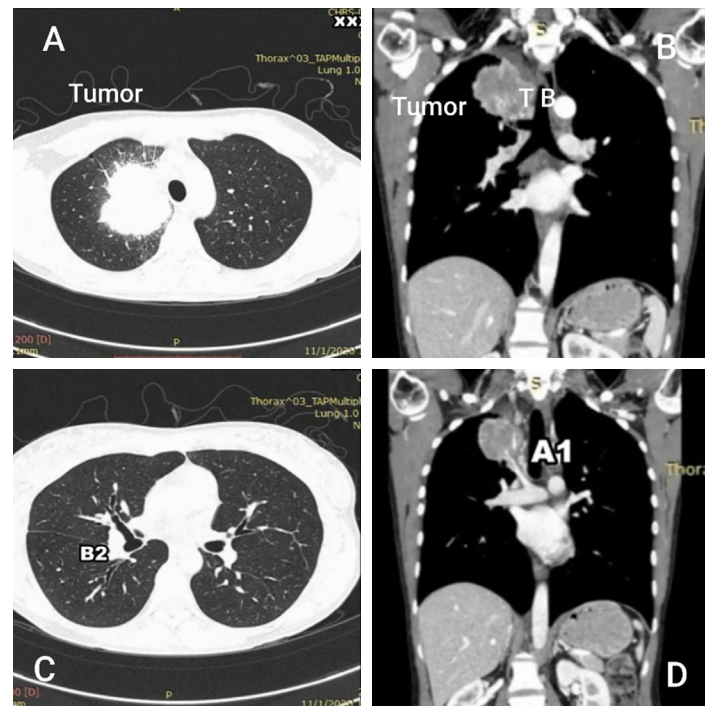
A: axial view of CT thorax showing a right upper lobe mass; B: coronal view of CT showing right upper lobe mass and tracheal bronchus; C: axial view of CT showing posterior segment bronchus (B2) originating from intermedius bronchus; D: coronal view of CT thorax showing artery to apical segment (A1) arising from the right main pulmonary artery. TB: tracheal bronchus
